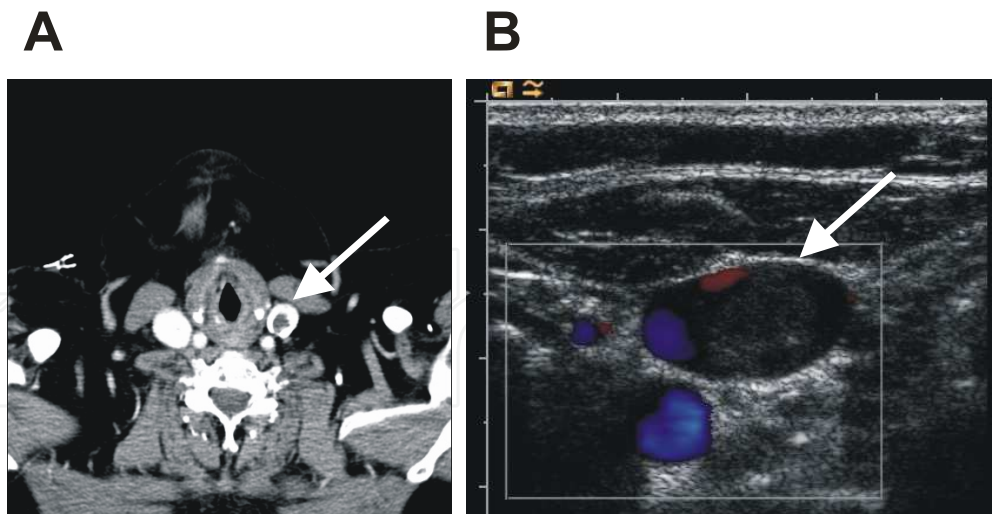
Computed tomography scan (A, Department of Radiology, Innsbruck Medical University) and colour duplex ultrasound (B) of the same patient showing a floating thrombus in the left internal jugular vein.
